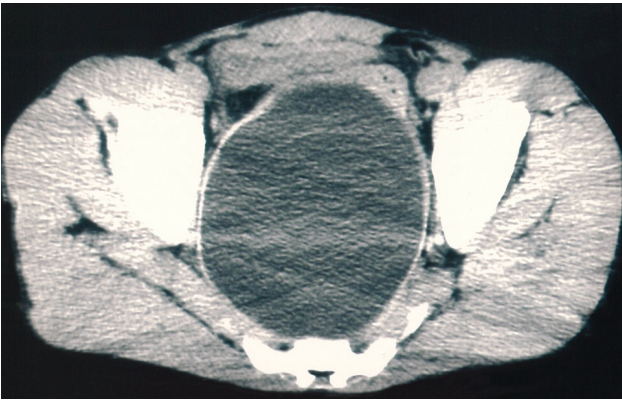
Non-contrast computed tomography revealing 15 cm mass of pelvic hydatid cyst. Note the compression of both the bladder and the rectum
